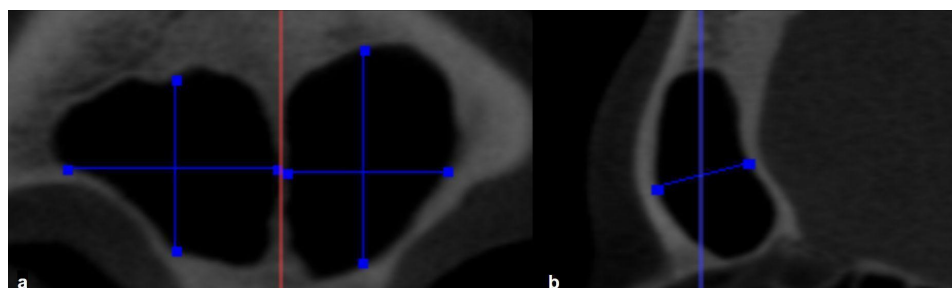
Frontal sinus linear measurements on a CBCT, using DDS-Pro™ software. a. Height and width in the coronal plane. b. Depth in the sagittal plane. Source: Own elaboration.
